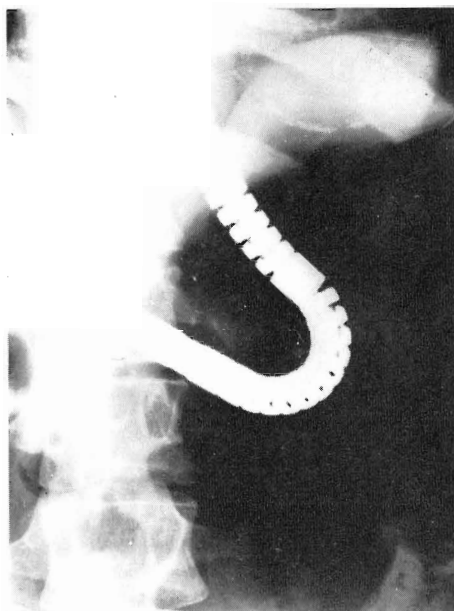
X-ray photograph during manipulation of Swan-type Double-bending Gastrofiberscope. When the upper flexible part is bent to  $140^\circ$ , the body of the scope is seen in the center of the visual field.
